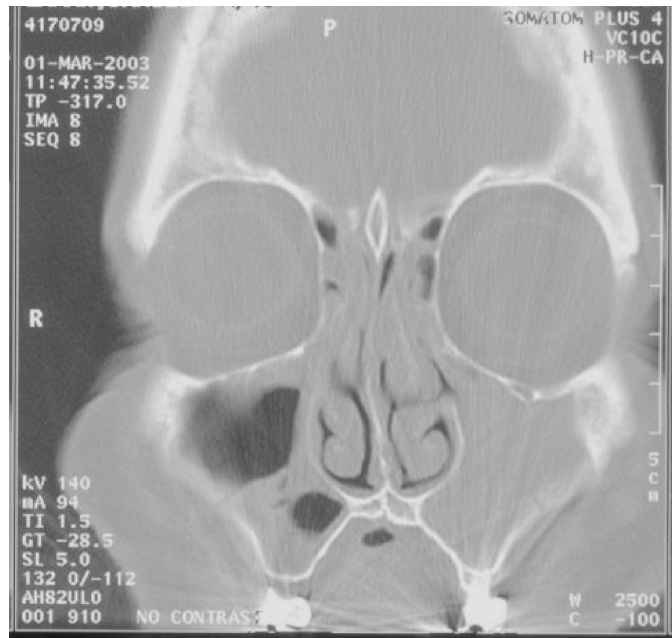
CT of sinuses showing opacification of ethmoid and maxillary sinuses.
